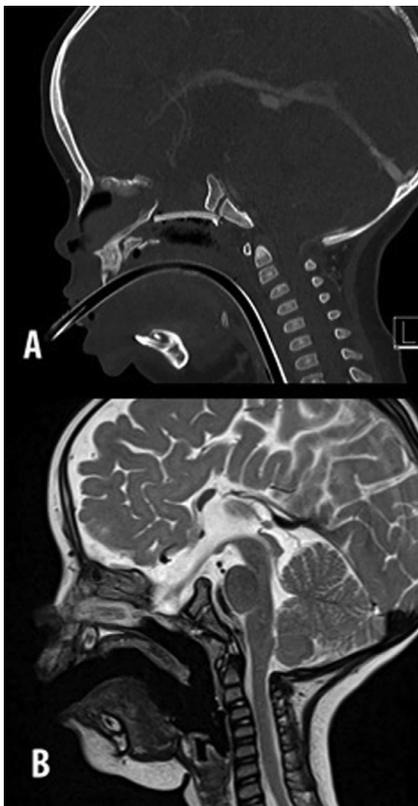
(A) Postoperative CT scan showing bone flap in place. (B) T2 MRI obtained 4 months postoperatively, showing stable reduction of encephalocele. Patient is now 2 years postoperation with stable vision and endocrine function. CT, computed tomography; MRI, magnetic resonance imaging.
